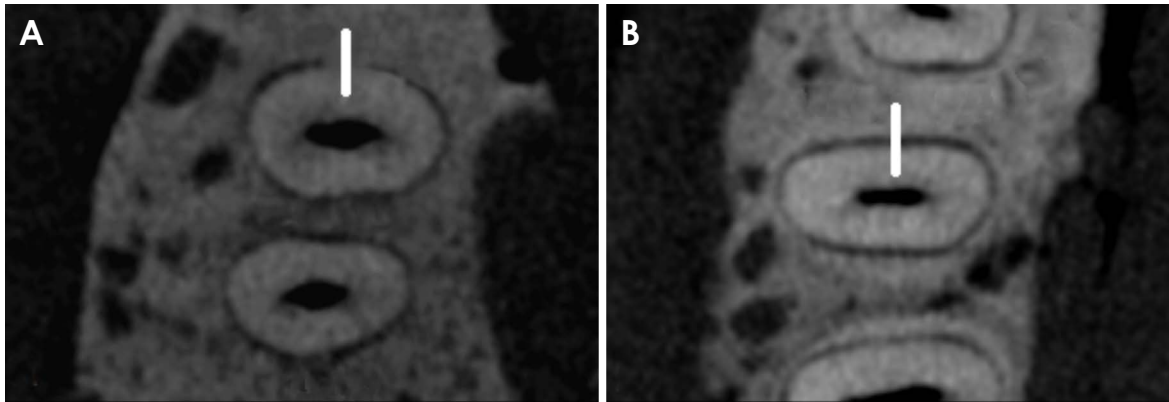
Representative cropped cone-beam computed tomographic axial reconstructions with the line of interest (white solid line) placed over an ankylosed region (A) and a non-ankylosed region (B).
